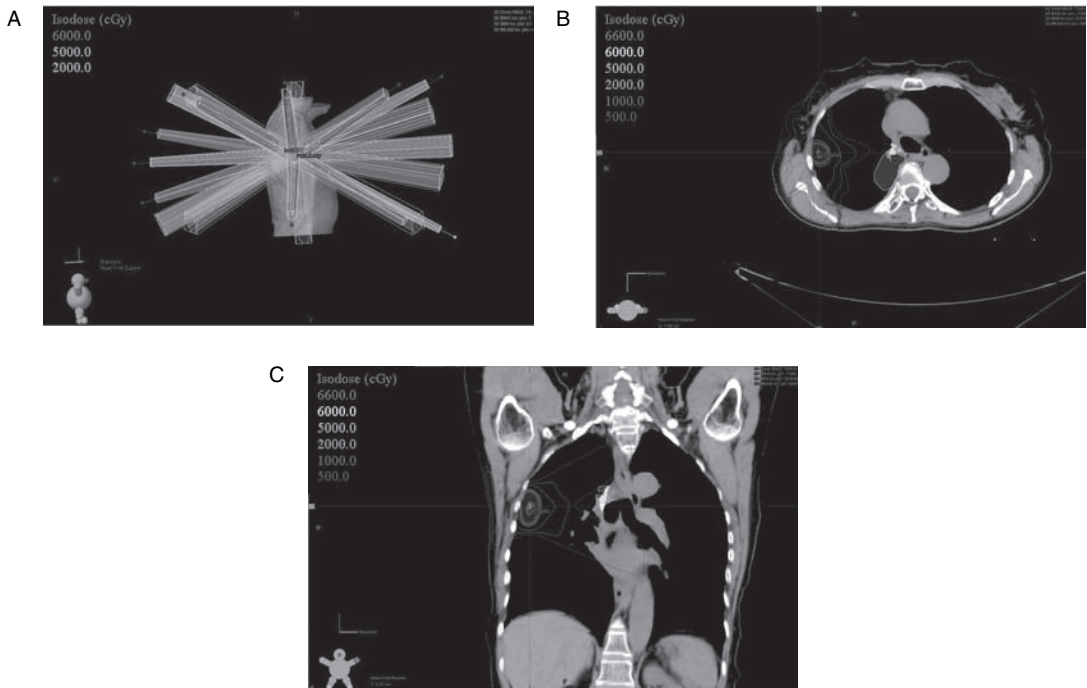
A. A beams eye view of a patient with a medically inoperable right lung cancer demonstrates multiple non-coplanar SBRT beams entering (and exiting) the patients external contour (shown in gray). B. A coronal computed tomography (CT) image shows the conformal dose around the lung cancer. C. An axial CT image shows the conformal dose around the lung cancer.
